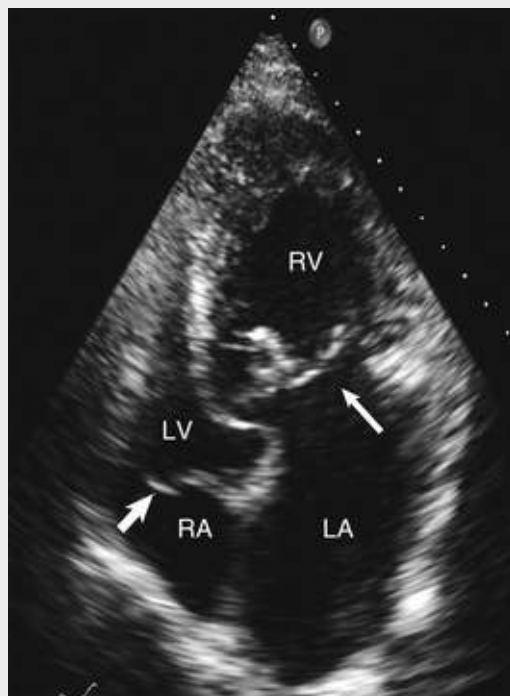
Apical four-chamber view in patient with L-transposition of the great arteries. The ventricles are inverted with the right ventricle (RV) to the right, identified on the basis of its heavy trabeculation and tricuspid atrioventricular valve (*thin arrow*). Although the insertion of the tricuspid valve is always apical to that of the mitral valve, in this case the offset is accentuated, consistent with the Ebstein anomaly. Unlike isolated Ebstein anomaly, that seen with L-TGA does not have a sail-like leaflet or adherence of the septal leaflet to the septum. The *thick arrow* points to the mitral valve. LA, Left atrium; LV, left ventricle; RA, right atrium.
